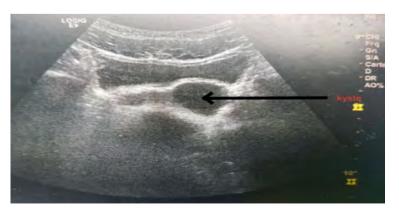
Abdominal-pelvic ultrasound showing a 22 mm left retrovesical cystic formation.
